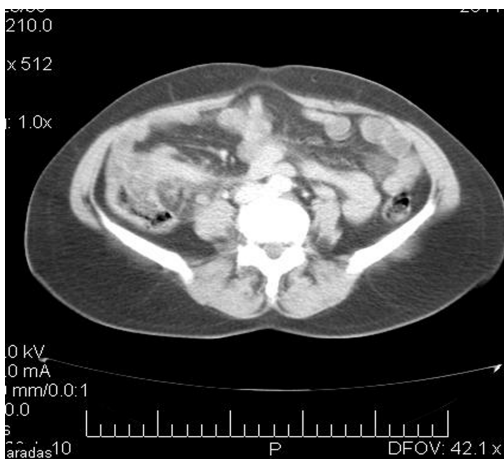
An axial abdominal CT image shows inflammatory changes of the cecum and pericecal fat tissue.
